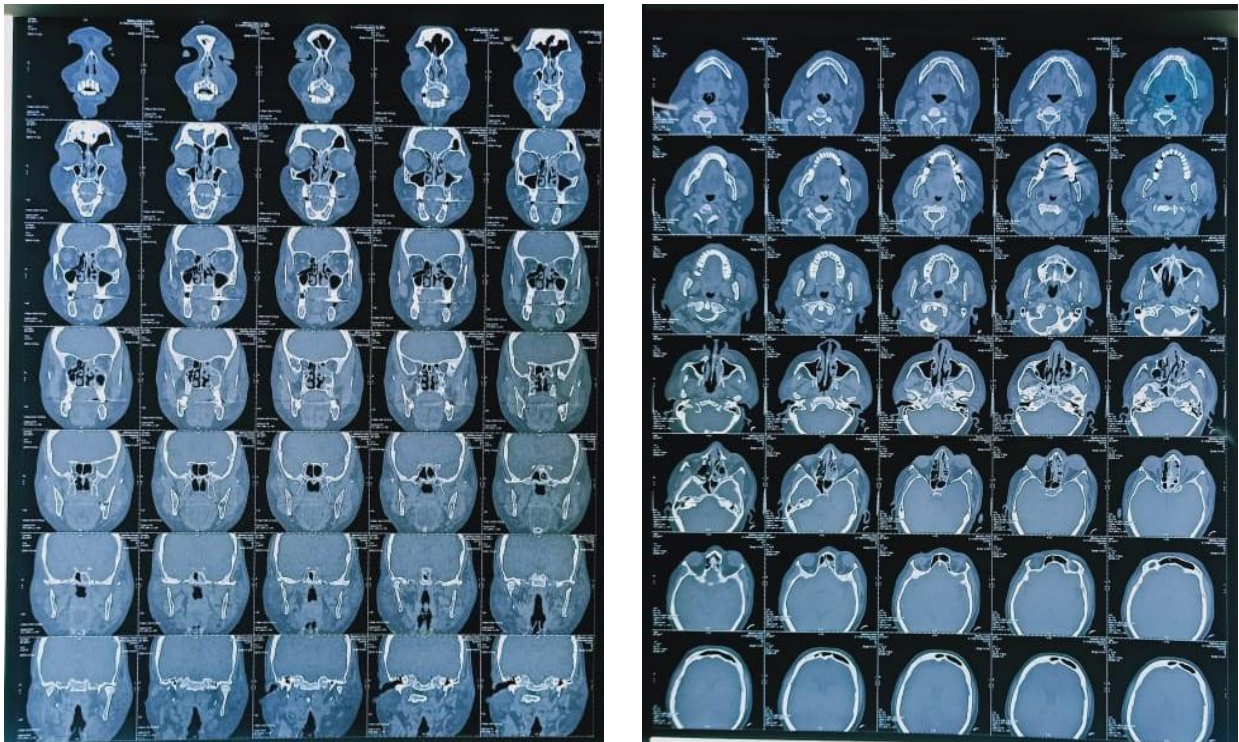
MRI reveals bone erosion of the posterior wall of the Right Orbit
